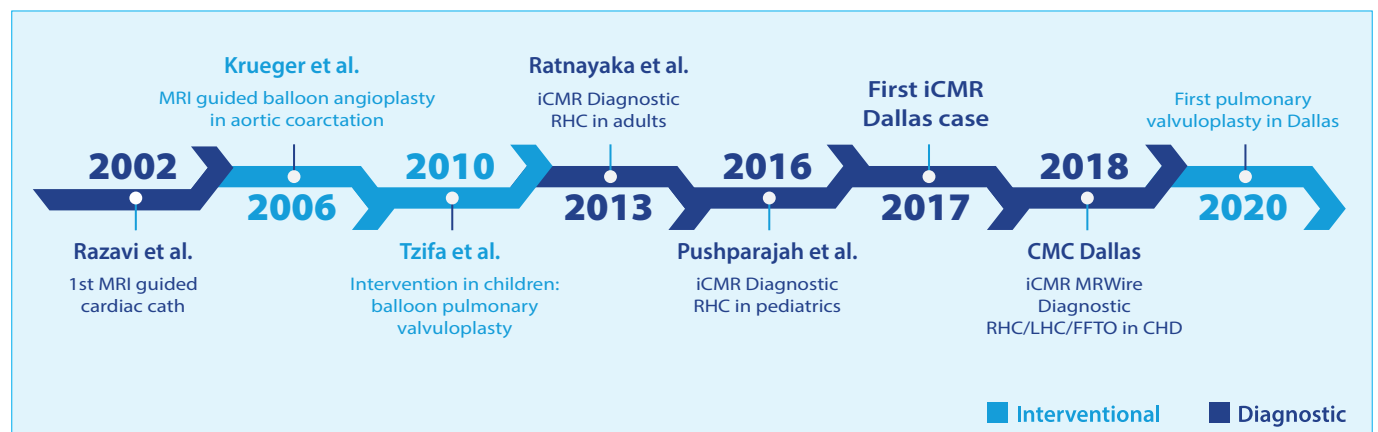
Between the discovery of X-ray in 1895 and its first cardiac use in a cathlab by Werner Forsmann in 1927 took 32 years. A 48 year interval elapsed between its invention in 1974 and first interventional use of MRI in 2006. It is anticipated that the incremental use of MRI will lead to a gradual decrease in X-ray in the next 40 years. The graph above shows the MRI guided cath evolution in human subjects over the past 25 years. Slide drafted on info of Dr. Greil (UT Southwestern Dallas).
